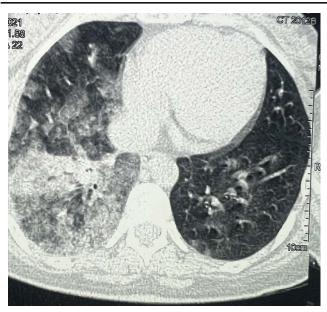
Chest computed tomography scan shows diffuse right ground glass opacities and consolidation, and a few left peripheral ground glass opacities.
